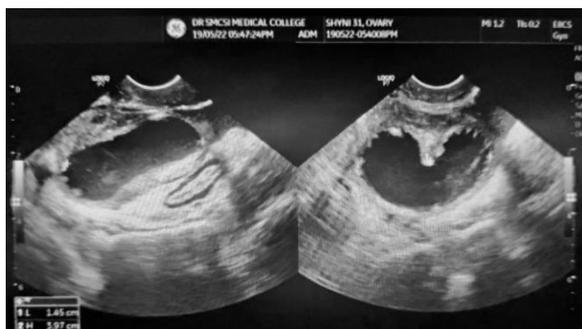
Ultrasonogram revealed a 6.6x5.8x3.6 cm heterogenous mass, solid component 3x2 cm with moderate vascularity, multiple thick septations (max 3mm) in the right adnexa close to the right ovary, with minimal free fluid in the pouch of douglas.
